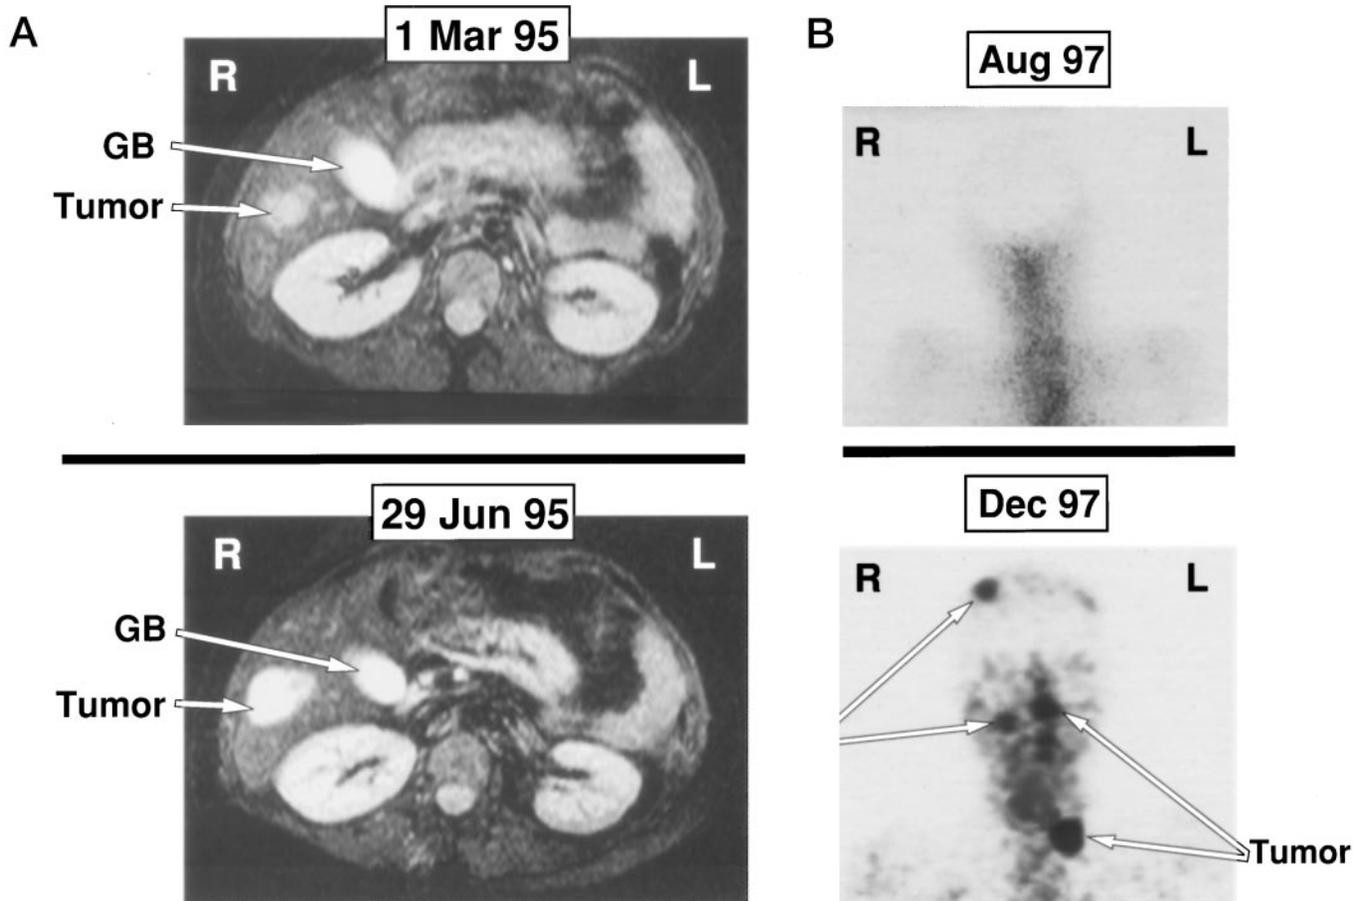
A patient with ZES and MEN1 with aggressive disease, with development of bone metastases and increasing liver metastases. The MRI short inversion-time inversion-recovery images (*left panels*) show a right hepatic lobe metastasis increasing in size over 4 months, and the SRS (*right panels*) show the development of bone metastases over a 5-month period. This patient (NIH 168978) had a prior history of duodenal gastrinoma resection with a subtotal pancreatectomy for a 3-cm pancreatic endocrine tumor and developed liver metastases 3.5 yr later. Metastatic gastrinoma was confirmed by percutaneous CT-guided liver biopsy. Tumor growth continued despite treatment with chemotherapy (streptozotocin-5-fluorouracil-adriamycin), interferon- α , and octreotide as described in *Subjects and Methods*. She died shortly after developing bone metastases. She also had hyperparathyroidism and a gastric carcinoid tumor.
